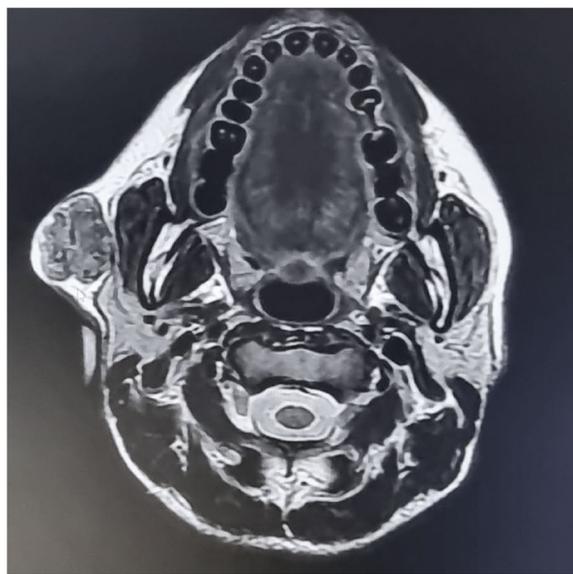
MRI: tumor with an extension to the right parotid superficial lobe
